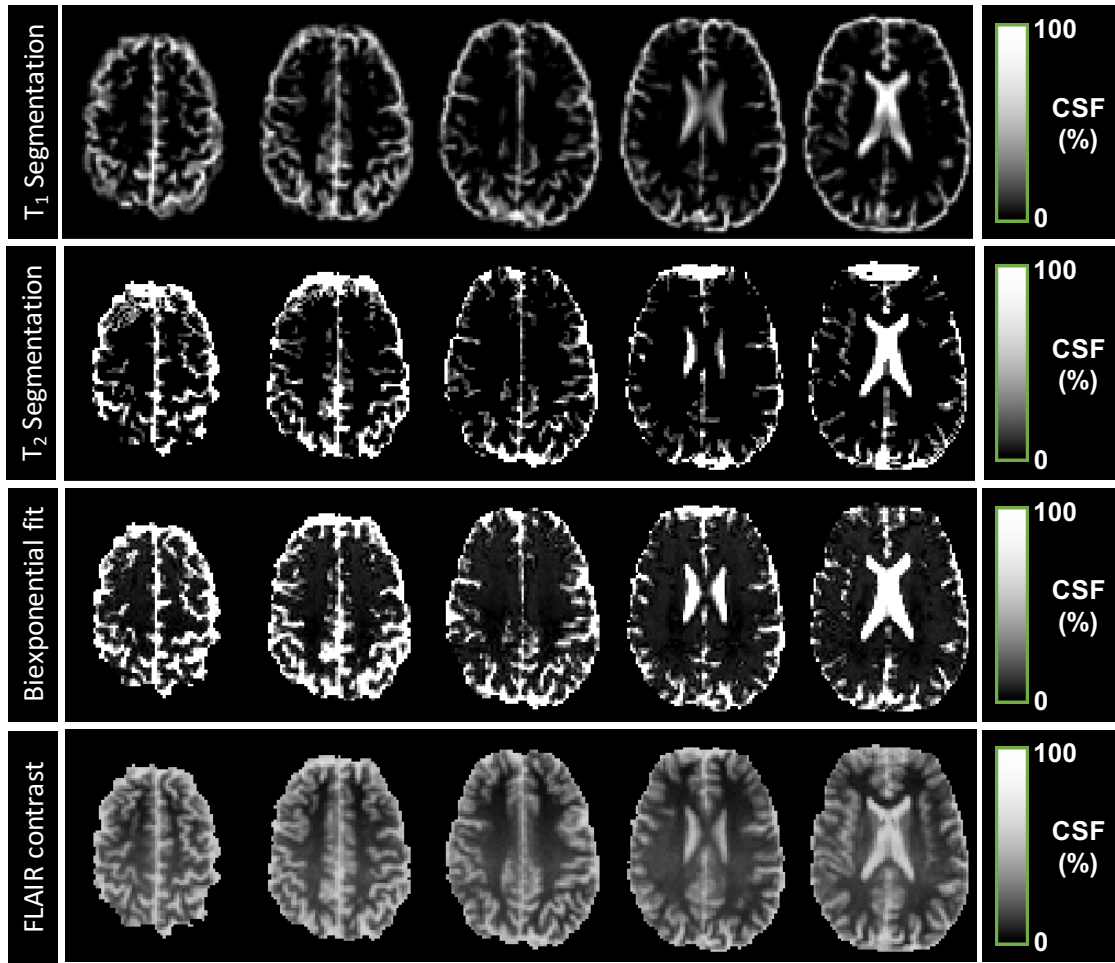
Example maps of CSF partial volume from a single healthy subject, obtained by four methods: First row: Segmentation of T_1 -weighted image. Second row: Segmentation of T_2 -weighted image. Third row: Biexponential model-fitting to T_2 data. Fourth row: FLAIR contrast model fitting.
